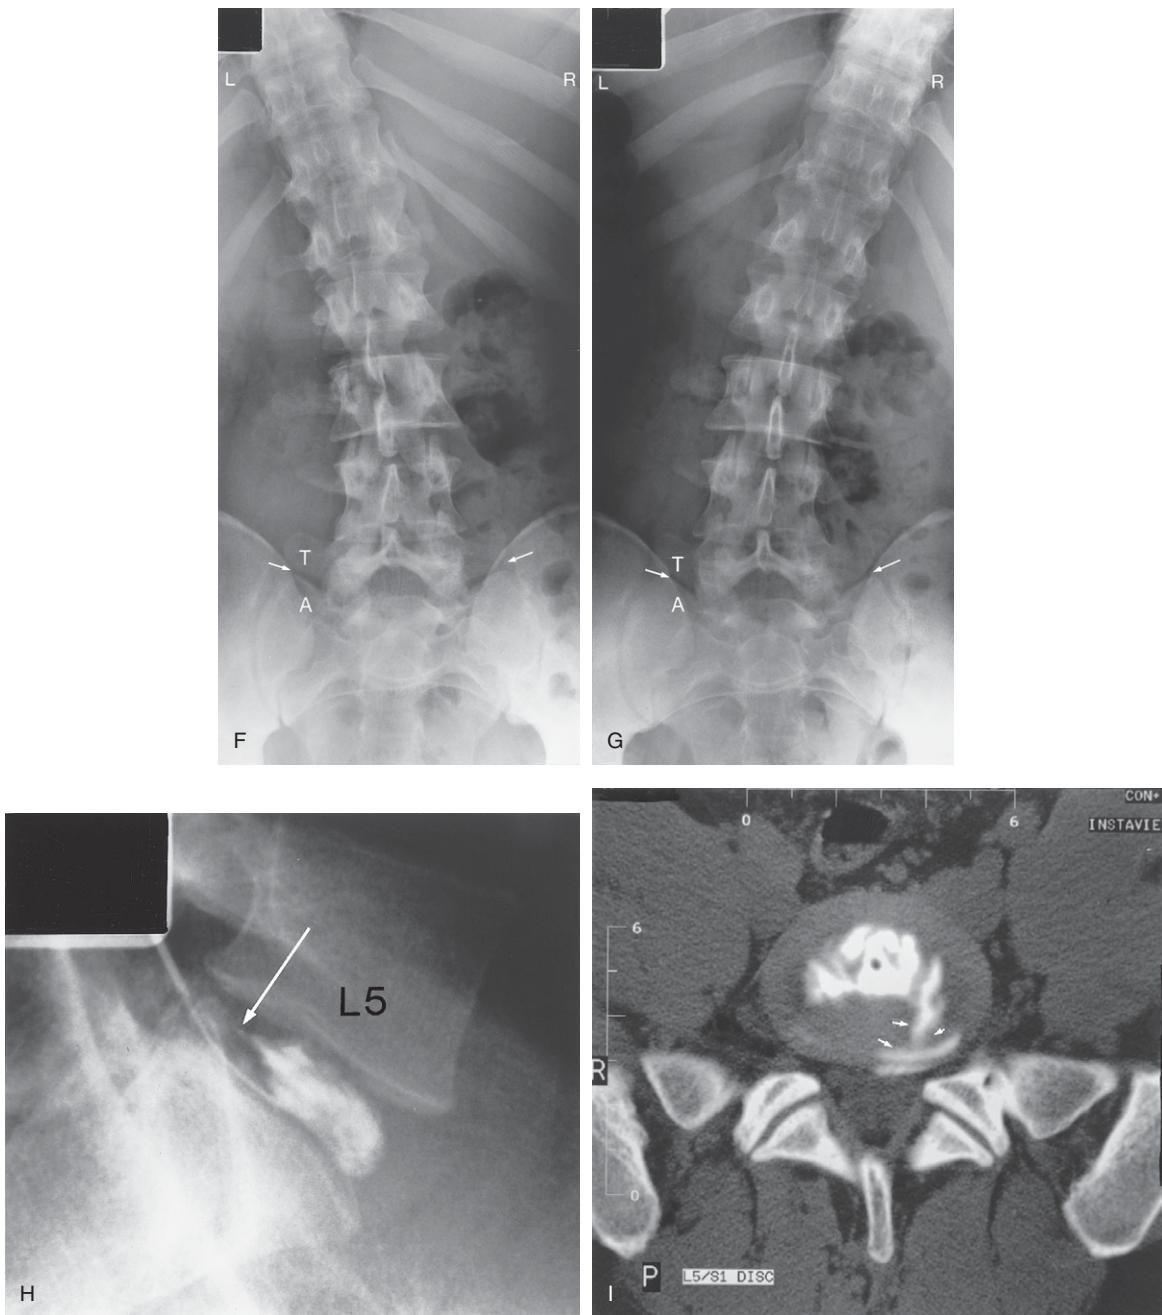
Cont'd (F) Lumbosacral spine erect posture left lateral bending anteroposterior image. Note that the disc spaces above the L5 vertebra wedge from being narrow on the left to wide on the right. However, there is apparently no movement between the transverse processes (T) of L5 and the sacral ala (A) (white arrows). (G) Lumbosacral spine erect posture right lateral bending anteroposterior image. Note that the disc spaces above the L5 vertebra wedge from being narrow on the right to wide on the left. However, there is apparently no movement between the transverse processes (T) of L5 and the sacral ala (A) (white arrows). (H) Lateral image discogram of the L5-S1 disc which shows tracking of the contrast medium posteriorly (arrow). (I) Lumbar spine CT axial image of the L5-S1 disc containing contrast material following the discogram which clearly shows a full thickness left posterolateral tear in the annular fibres (arrows) with some internal disc disruption centrally.
